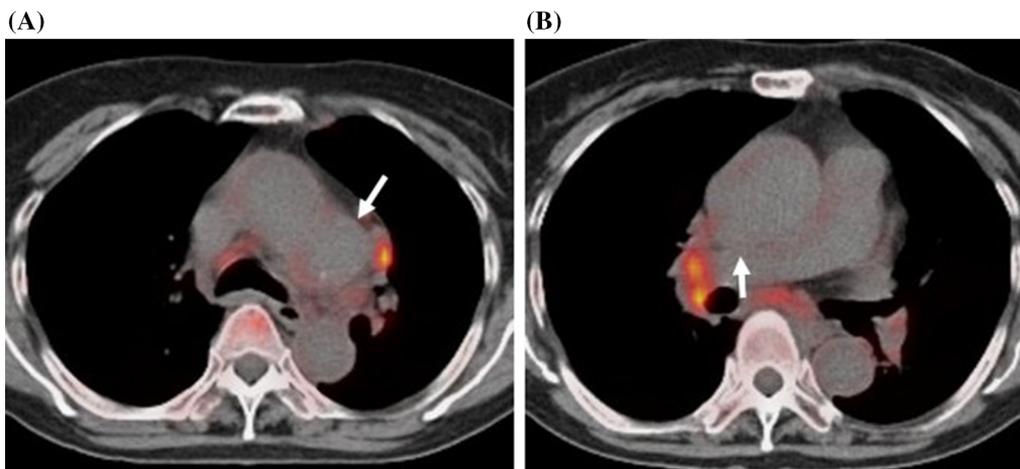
One month after antibiotic treatment, ^{18}F -FDG PET/CT fusion images (A, B) showing decreased FDG uptake within the wall of aortic arch (arrow) and ascending aorta (arrow). ^{18}F -FDG PET/CT fusion images also show decreased uptake in the sternum and hilar and mediastinum lymph nodes.
